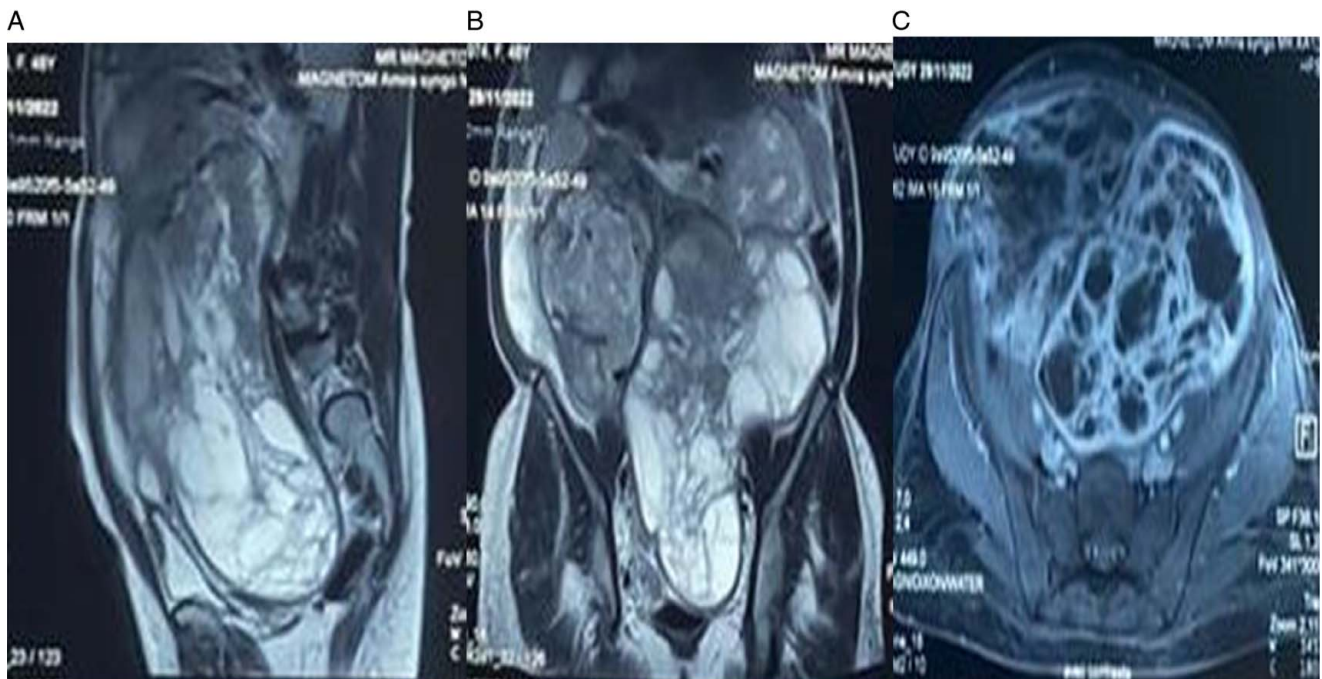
Uterine leiomyomatosis in cystic degeneration occupying the abdomino-pelvic cavity. coronal MRI T2 (A), sagittal T2 (B) and axial sequence after injection of gadolinium (C) Shows large masses with uterine origin, occupying the abdominal cavity, with heterogeneous signal, containing cystic areas in T1 hyposignal and T2 hypersignal, and tissue portions in diffusion hyposignal, homogeneously enhancing in relation to the myometrium.
